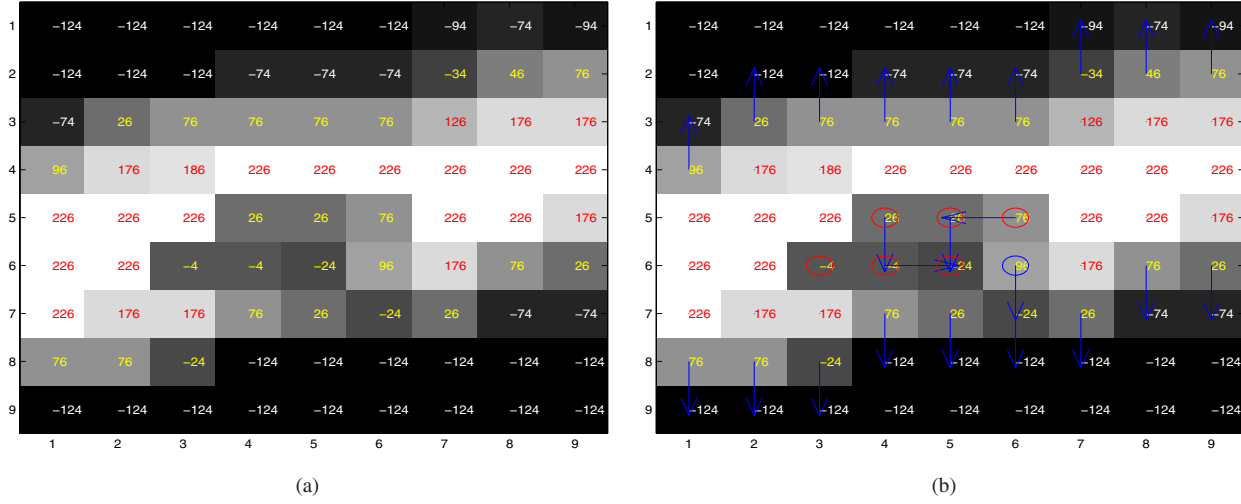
This 2D artificial image was created to resemble a small artery with pulmonary embolism. Pixels with CT values below -50 HU in white, pixels with CT value above 100 HU in red and all other pixels in yellow. Naturally, all the PE pixels are in yellow. However, due to partial volume effects, the pixels around the artery boundaries are also in yellow. It is also true for the airway boundaries (not shown here). Therefore, for automatic PE detection, it is crucial to remove the pixels around the artery boundaries and those around the airway boundaries, while preserving the PE pixels. This can be done with tobogganing by sliding all the yellow pixels to its neighbor with minimal CT value (2D four-connected neighborhood used in this example), and collecting all pixels that don't slide into regions with Hounsfield Unit below -50 HU, forming PE detections (*i.e.*, PE regions or PE clusters). As a by-product from the tobogganing process, the PE detected regions along with the pixels with CT value above 100 HU (in red) form a rough vessel segmentation. This paper utilizes this rough vessel segmentation in computing the geodesic distance between each pair of PE candidates.
